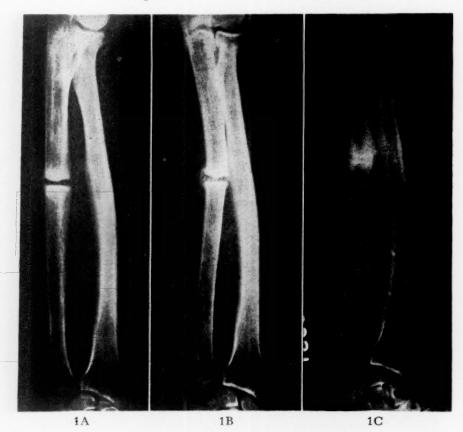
A, radiograph in 1951 of right ulna fracture before treatment. Note minimal calcification of callus and coarsened trabeculae. B, radiograph in 1956 after five years of vitamin D and calcium therapy. Note further calcification at fracture site and lessened trabeculation. C, radiograph in 1957 after the addition of oral phosphorus supplements, showing complete healing of previous fracture.
